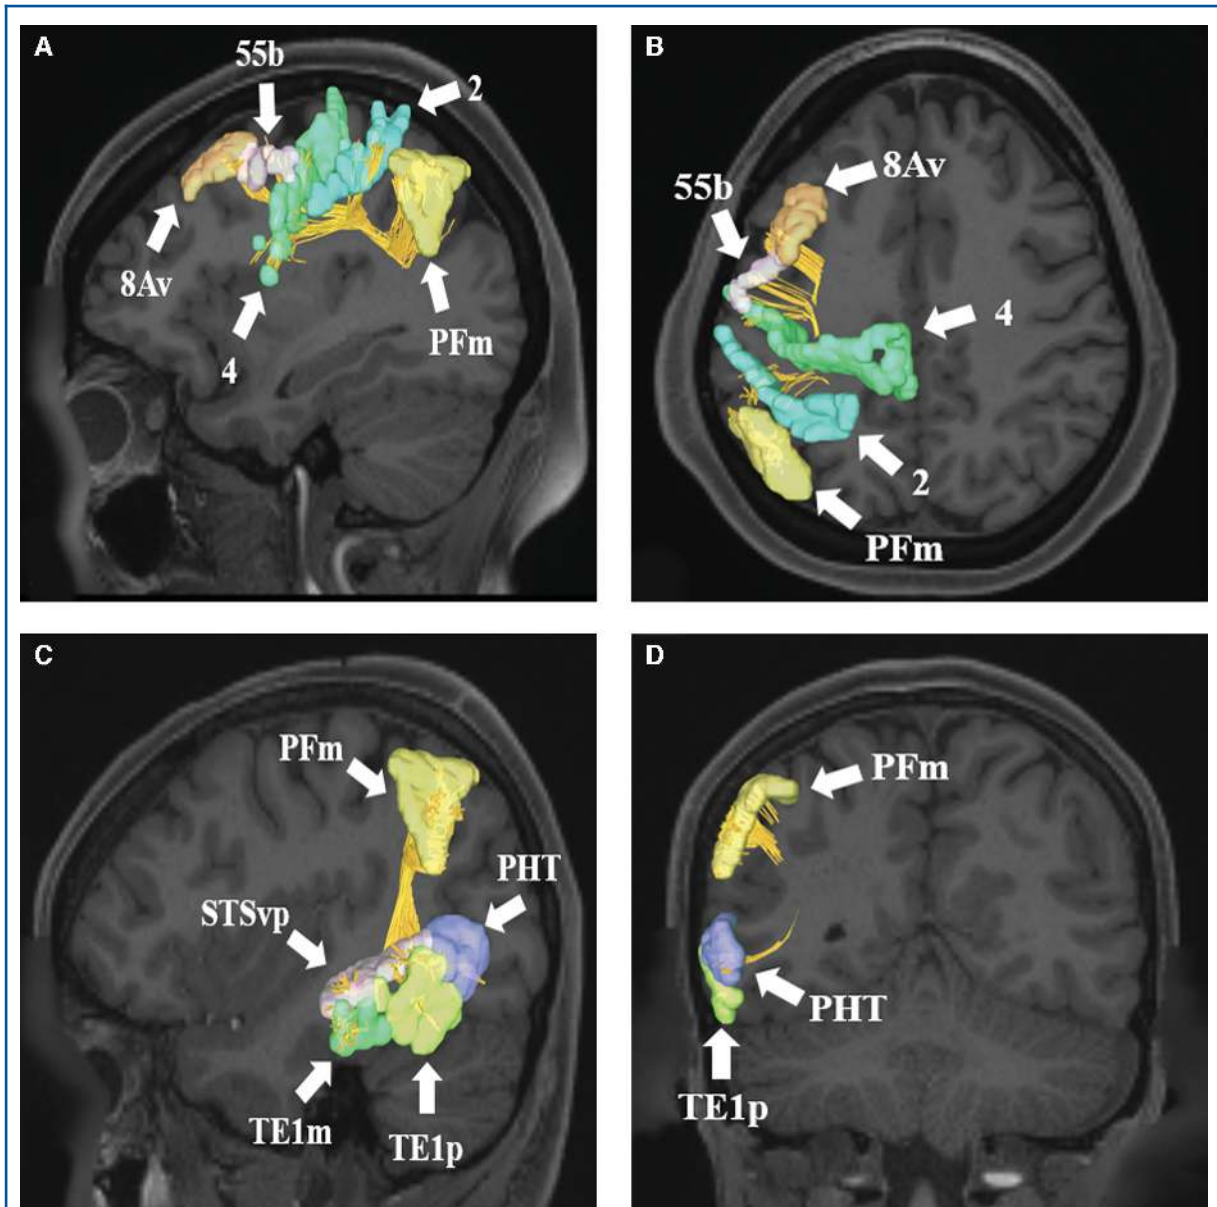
SLF connections from inferior frontal sulcus area PFm. Area PFm demonstrates structural connections to A and B, areas 2, 4, 55b, and 8Av anteriorly and C and D, areas STSvp, TE1m, TE1p, and PHT inferiorly. These connections are shown in the left cerebral hemisphere on T1-weighted MR images in the A and C, sagittal and B and D, axial planes, respectively. All parcellations are identified with white arrows and corresponding labels.
